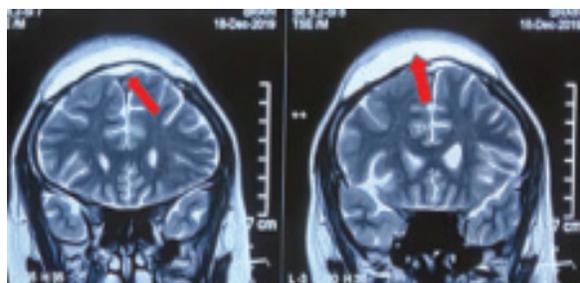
Follow up magnetic resonance imaging T2W coronal images showing inflammatory collection at operation site and around G-patch
